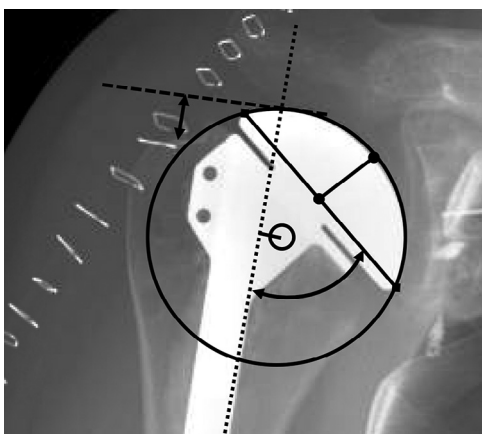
This anteroposterior radiograph demonstrates each of the measurements, including head height (line with circle ends), head diameter (line with square ends), tuberosity-to-head height (double-sided straight arrow), inclination (double-sided curved arrow), and medial offset (solid line with blunt end).
